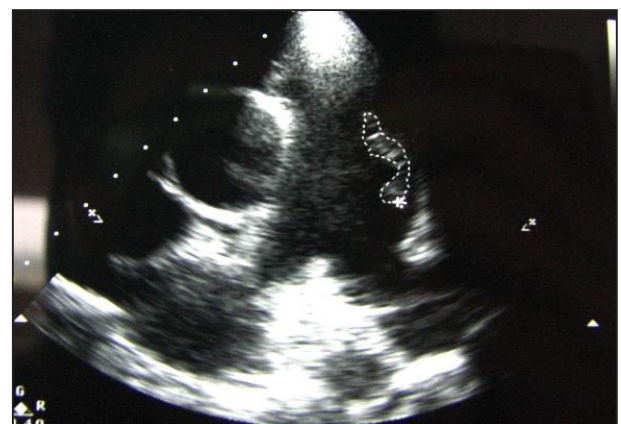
Transthoracic echocardiogram showing vegetation (0.9 cm) in main pulmonary artery.
